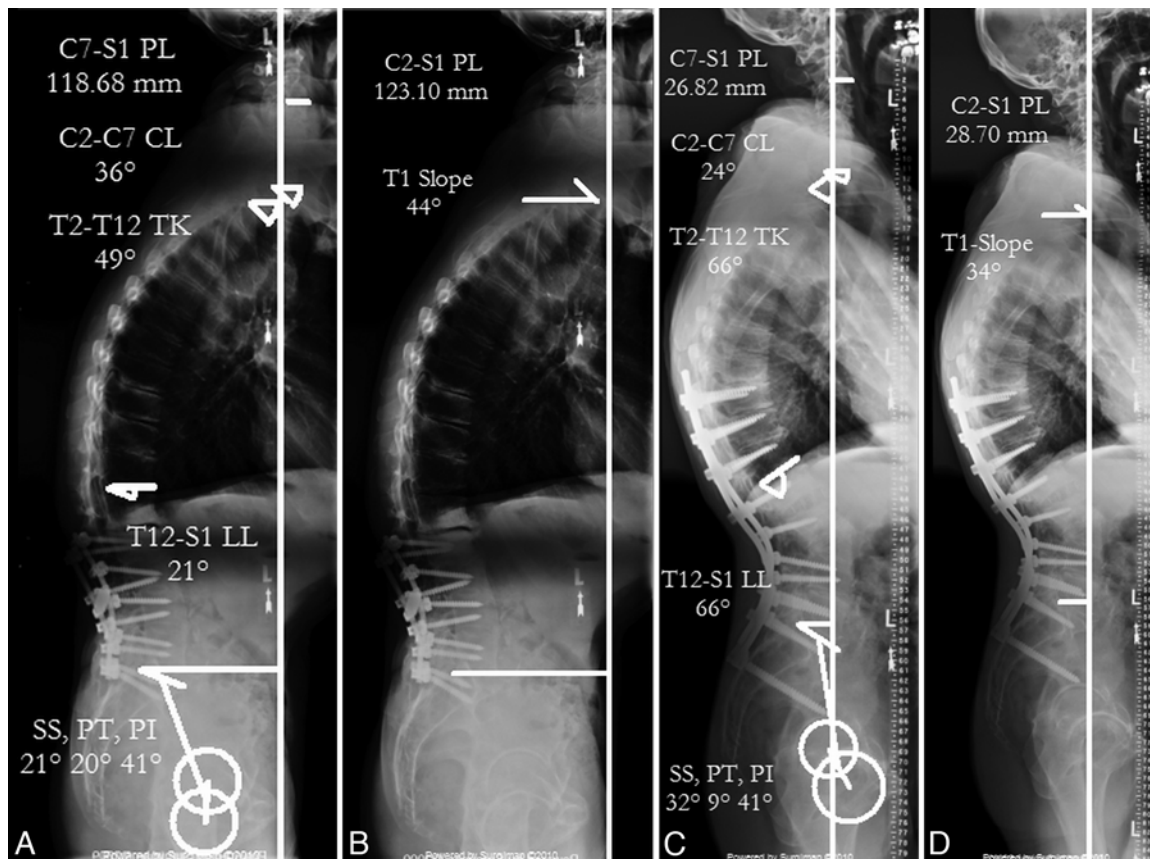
Case example. Preoperative (A and B) and postoperative (C and D) sagittal radiographs showing measurement markup. Note the decrease in cervical lordosis following lumbar PSO. CL = cervical lordosis; PL = plumb line.
